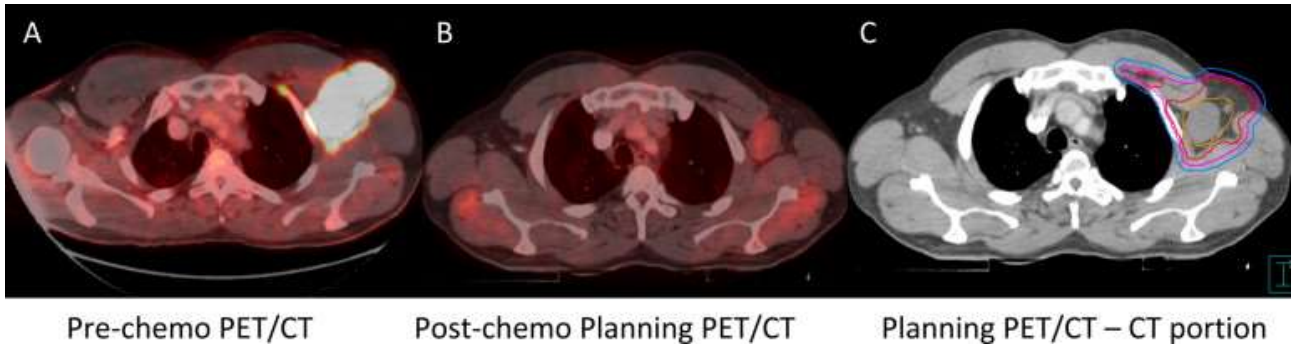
(A-C) A 48-year-old man with stage 2AX diffuse large B-cell lymphoma of the left axilla presented with a rapidly growing underarm mass. (A) Baseline positron emission tomography (PET)/CT imaging shows extent of disease. (B) After 6 cycles of Rituximab-Cyclophosphamide, Adriamycin, Vincristine, Prednisolone (R-CHOP) fluorodeoxyglucose uptake resolved, leaving residual CT abnormality only. (C) Treatment volumes are outlined on the treatment planning scan according to International Commission on Radiation Units and Measurements guidelines; orange contour denotes postchemotherapy gross tumor volume, red denotes prechemotherapy gross tumor volume, pink denotes clinical target volume, and light blue denotes planning target volume.
